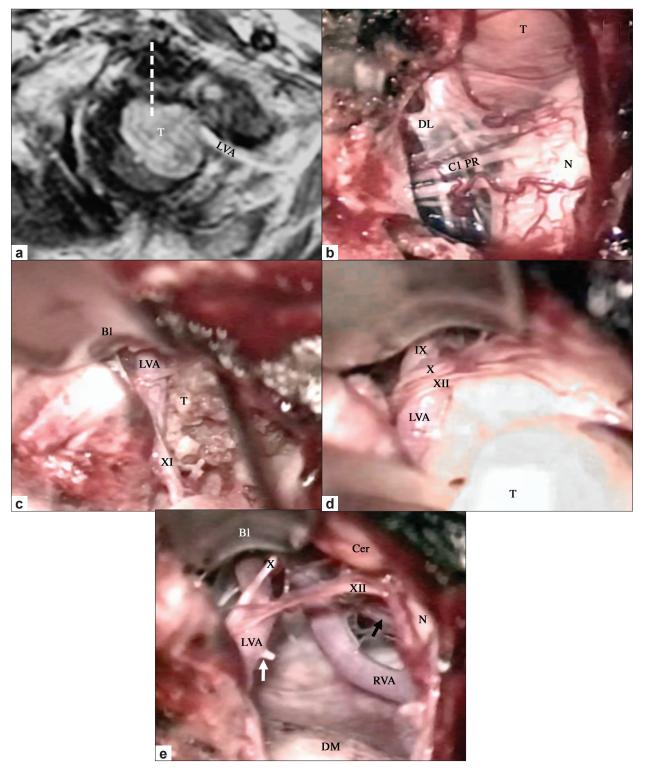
Anterior intradural foramen magnum meningioma developed below the vertebral artery. (a) Preoperative view on axial TI-weighted MRI with gadolimium administration. The tumor (T) inserts on both sides of the midline (dotted line). The left vertebral artery (LVA) passes above the tumor. (B-E Operative views. (b) View just after the dura opening. (c) The tumor is developed below the vertebral artery. (d) The lower cranial nerves are identified at the superior aspect of the tumor. (e) Final view. White arrow indicates a feeding vessel that has been divided. Black arrow shows the right PICA. BI: blade. CI PR: CI posterior rootlets. Cer: cerebellum. DL: dentate ligament. LVA: left vertebral artery. N: neuraxis. T: tumor. IX: glosso-pharyngeal nerve. X: vagal nerve. XI: accessory nerve. XII: hypoglossal nerve. Modified with permission. [1]
